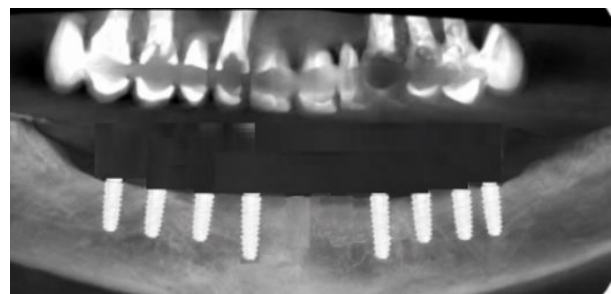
Postoperative CBCT, Placement of eight BioHorizons implants in the regenerated mandibular ridge demonstrating appropriate positioning and primary stability.
